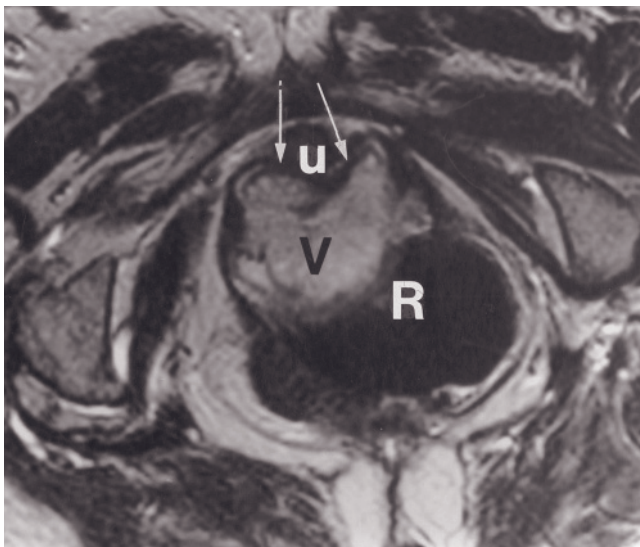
Extensive vaginal lymphoma. Axial (a) and coronal (b) T2-weighted ETSE images demonstrate a large, lobulated intermediate-signal-intensity mass filling the vaginal canal, displacing the uterus, and extending through the introitus.
